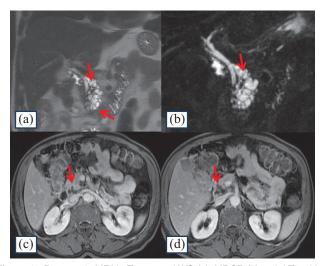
Pancreatic MRI in T2 coronal WS (a), MRCP (b), axial T1 with contrast enhancement WS (c, d) confirming intramural and inter duodenal-pancreatic cysts (red arrow).
